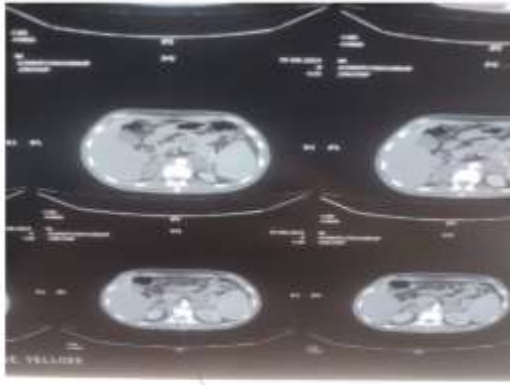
CT abdomen showing -Diffuse enlargement of bilateral adrenal glands (right gland- 6.1*3.3; left gland 6.3*2.9cm)
